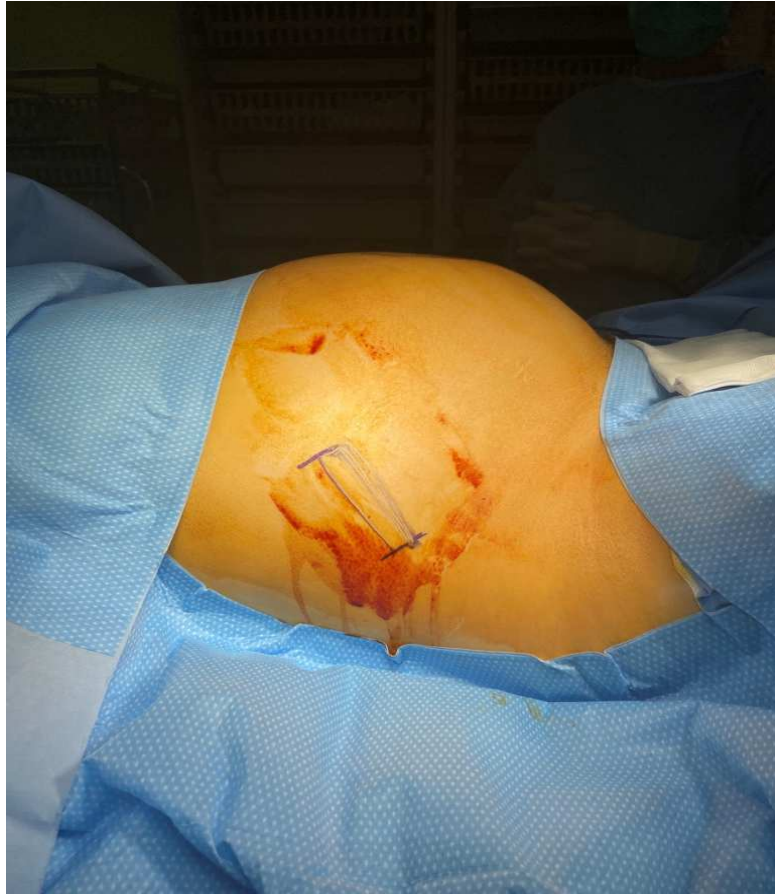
Ultrasound tracking before surgery
